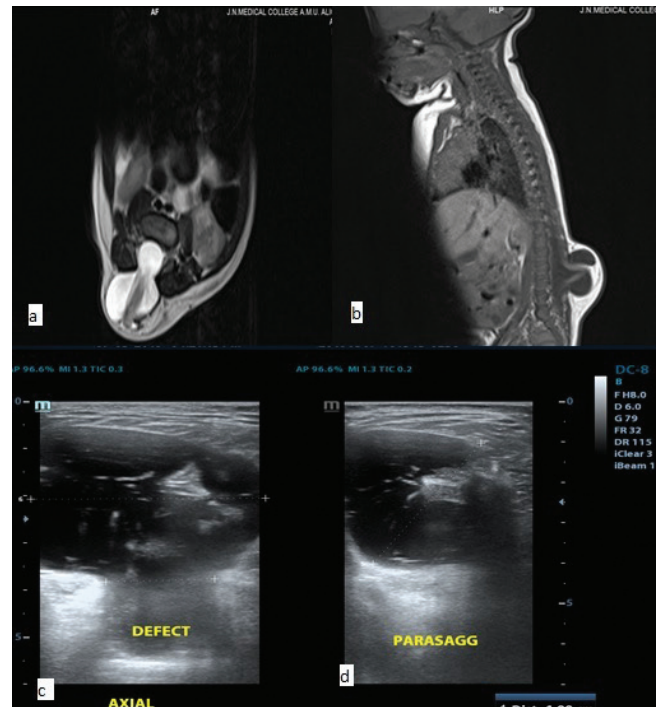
(a,b): T2 weighted axial and T1 weighted sagittal images showing herniated spinal cord and neural elements in a case of lipo-myelomeningocele. (c,d): Transverse and parasagittal views of high resolution ultrasound spine in the same patient.
